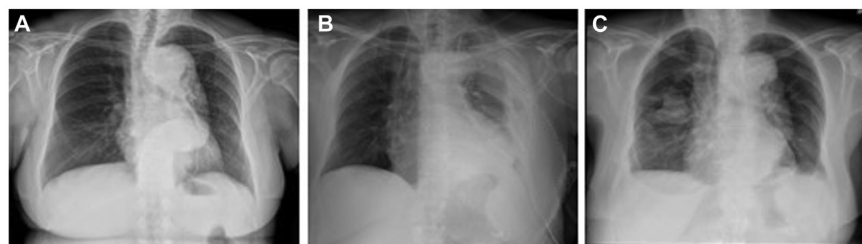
Chest radiograph performed at admission (A), after thoracoabdominal aortic aneurysm (TAAA) open surgical repair (OSR) (B) and at discharge (C). Before the index open operation, the chest radiograph was normal (A). On postoperative day (POD) 6, the chest radiograph showed left pleural effusion, with areas of atelectasis and severe reduction of the pulmonary parenchyma (B), despite the chest tube still being in place. After TD ligation, the chest radiograph showed a complete resolution of the pleural effusion, without any signs of lung fluid collections or lung atelectasis (C).
